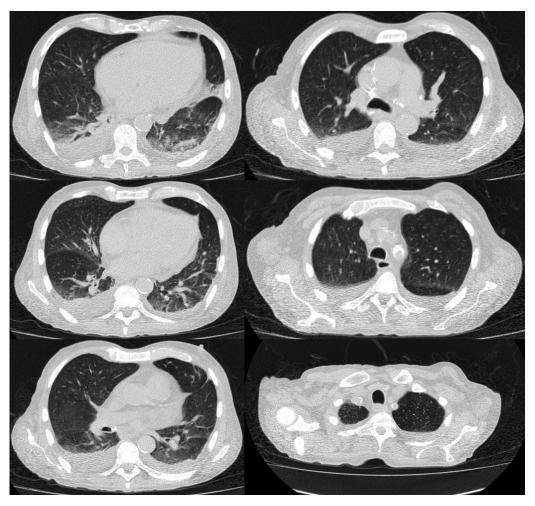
High-resolution computed axial tomography (HRCT) of the chest thorax in which silicoanthracosis, atelectasis of the lower lung lobes and altered density of the vertebral bodies and sternum.
